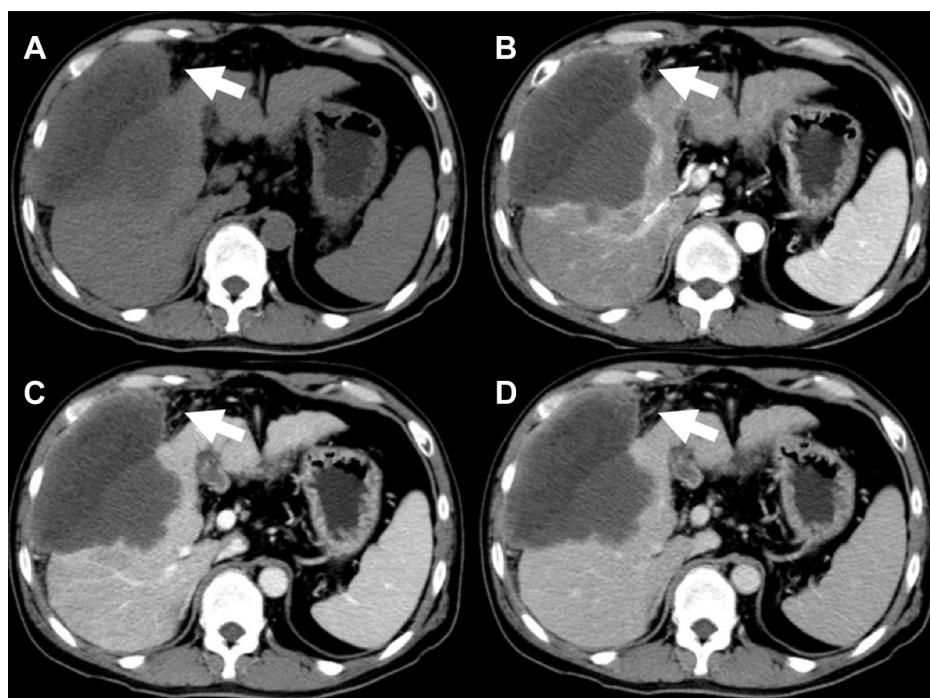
Computed tomography (CT) of the abdomen revealing a cirrhotic appearance of the liver with a complete cystic mass measuring $9.0 \times 9.5 \times 9.3$ cm (white arrows) in segments 5–7. (A) Noncontrast and dynamic CT; (B) arterial; (C) portal; and (D) delay phases demonstrated that the cystic mass showed no contrast enhancement or early washout. The portal vein was patent, and no peripheral bile duct dilatation was seen.
